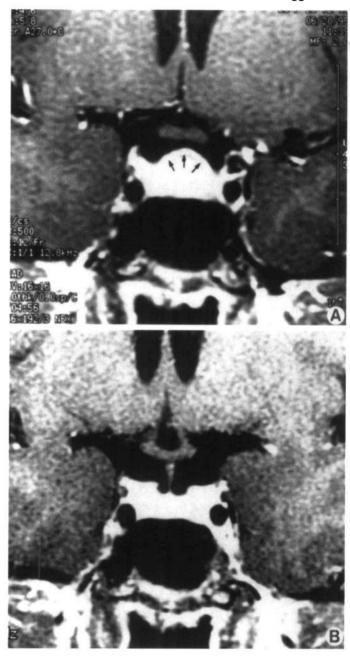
MRI of the pituitary in a patient with <sup>131</sup>I-induced hypothyroidism. A, Initial MRI after gadolinium demonstrates a large pituitary "tumor" with suprasellar extension and a rim of enhancing pituitary tissue that could be easily mistaken for normal pituitary gland (*arrows*). B, Follow-up MRI after gadolinium obtained 1 month later, after high doses of thyroid hormone therapy, shows complete resolution of suprasellar mass.
